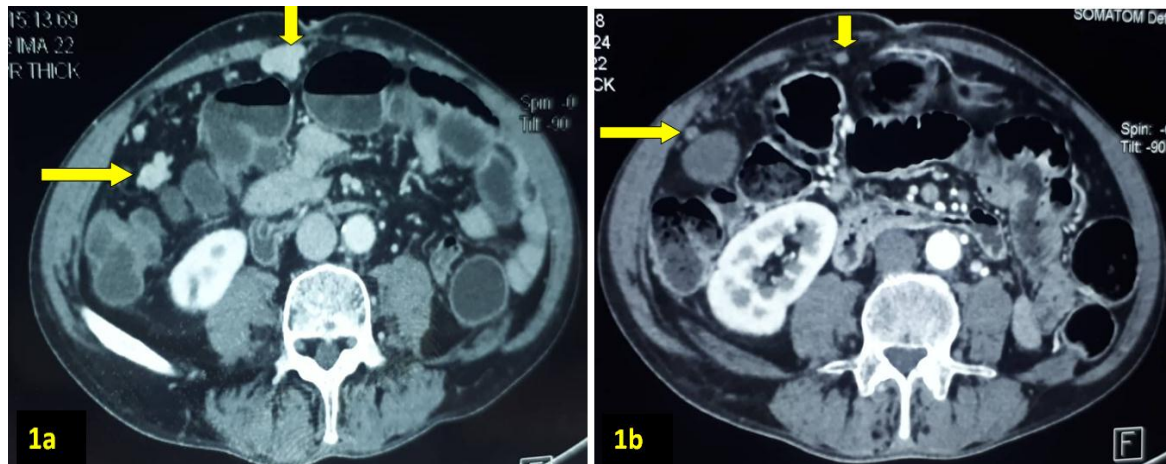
Fig. 1b: Contrast-enhanced computed tomography scan of peritoneal splenosis showing in the portal phase, oval nodules of homogeneous density with clear limits (arrows) and no infiltration of fat around.
